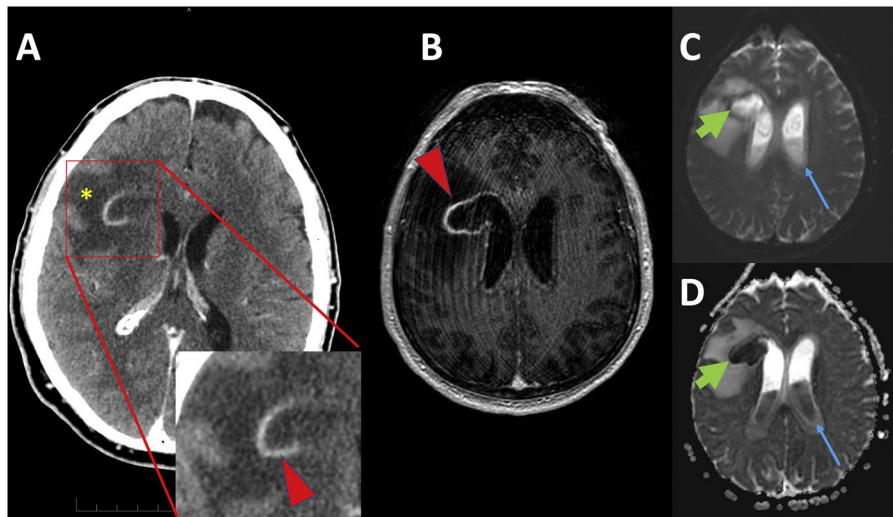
(A) Cranial CT scan: right frontal space-occupying lesion with ring enhancement (arrowhead), in close relation to the frontal horn of the right lateral ventricle, with moderate expansion effect and associated vasogenic oedema (asterisk). (B) 3D T1-weighted, DWI (C) and ADC (D) MRI sequences. The abscess shows markedly restricted diffusion in the diffusion sequence (thick arrows), with signs of ventriculitis (thin arrows).
